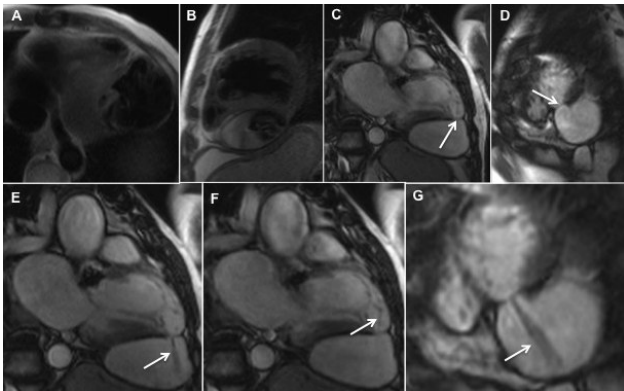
T2-w black-blood half-Fourier turbo spin-echo (HASTE) MR images - transverse (A) and sagittal (B) views show wall rupture of the left ventricular infero-lateral wall, resulting in a large left ventricular pseudoaneurysm with thrombus. Vertical long-axis view (C) and short-axis view (D) through the plane of the neck of the pseudoaneurysm, obtained with a fast steady-state cine MR imaging sequence, show a narrow interruption (arrows) of the infero-lateral left ventricular wall and formation of a bulging cavity. Note that the maximal width of the orifice is shorter than the maximal parallel internal diameter, a typical feature of false aneurysm. Oblique vertical long-axis view (E and F) and short-axis view (G) steady-state free precession MR images, through the plane of the neck of the pseudoaneurysm, clearly demonstrate the pseudoaneurysm and its communication with the left ventricle. There is a signal void jet flow (arrows) through the aneurysmal sac during the systole and another during diastole into the left ventricle.
